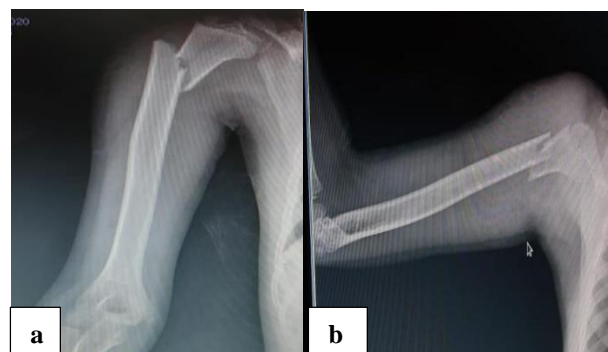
Image showing AP and lateral X-ray of arm with proximal third humerus shaft fracture (AO type 12A2).
